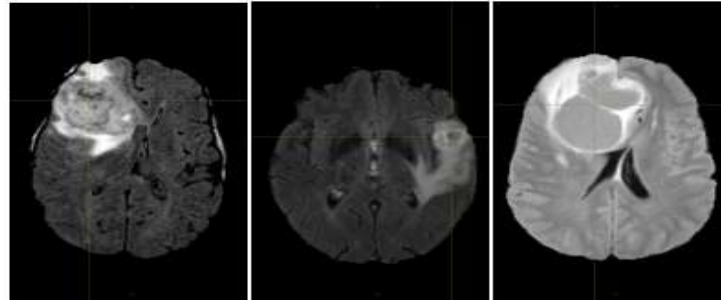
Axial slices of T2-FLAIR acquisitions of 3 different brains with tumors of variable grade [56]
